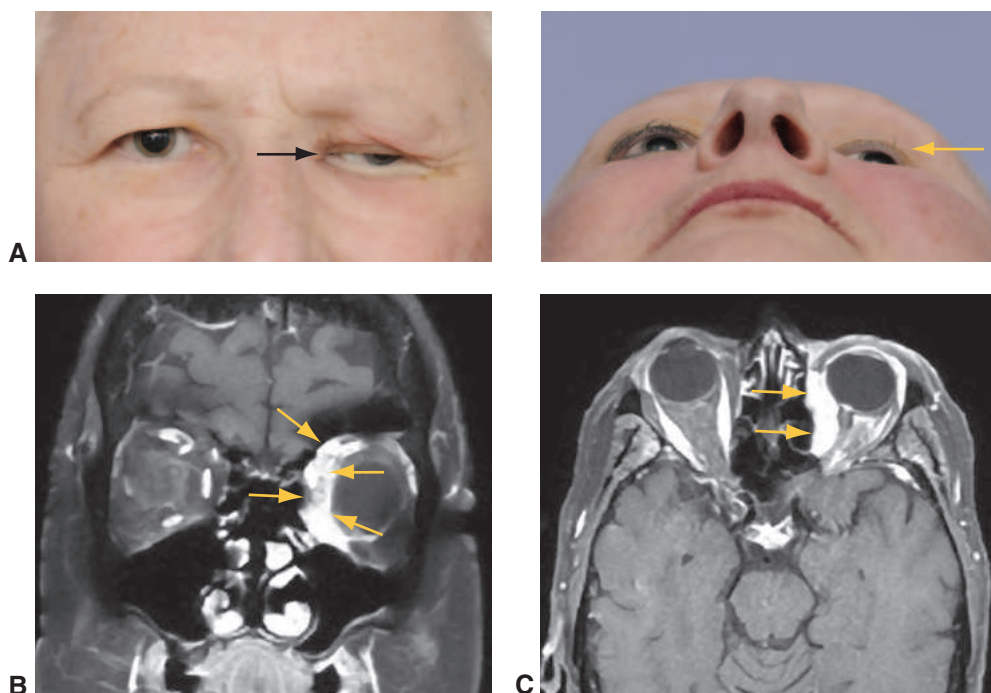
Metastatic breast carcinoma. A, Left enophthalmos (arrows) secondary to breast carcinoma metastasis to the orbit. Coronal (B) and axial (C) MRI images show medial infiltration of the orbit (arrows). (Courtesy of Hakan Demirci, MD.)
